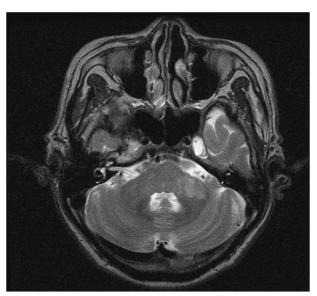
MRI finding in a patient with AICA artery territory infarction. T2-weighted MRI scan of the brain demonstrated hyperintense foci involving the left middle cerebellar peduncle. AICA: anterior inferior cerebellar artery.
